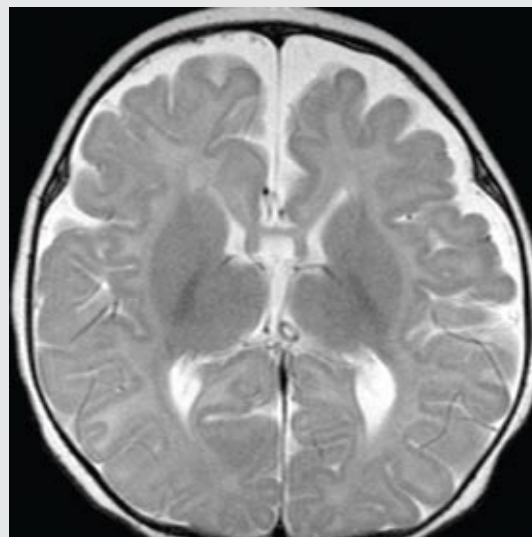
Magnetic resonance imaging scan: axial T2W SE at level of basal ganglia. There is bilateral hyperintense signal abnormality in the periventricular white matter associated with brain atrophy. No imaging findings of acute ischemia or cortical necrosis
